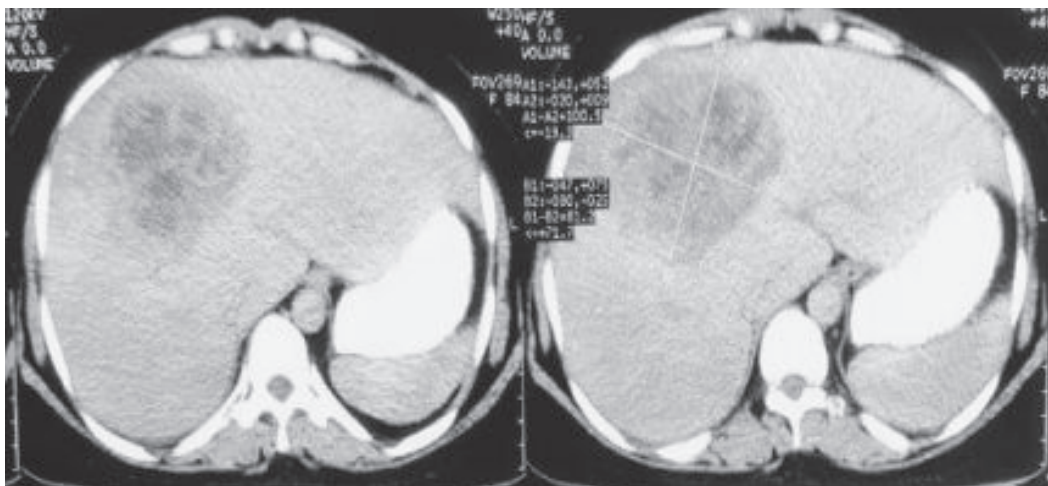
Axial post-contrast CT scan of the abdomen in a 30-year-old female with HCC shows arterial phase enhancement of the lesion in the liver (Case 47)
